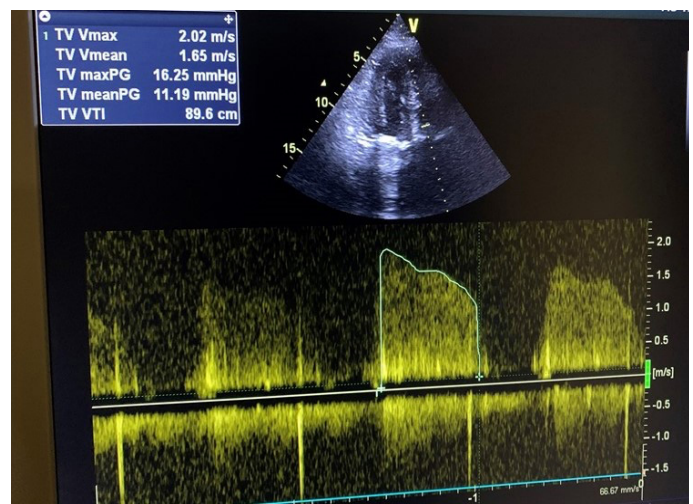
Pre-procedural Doppler echocardiographic image
